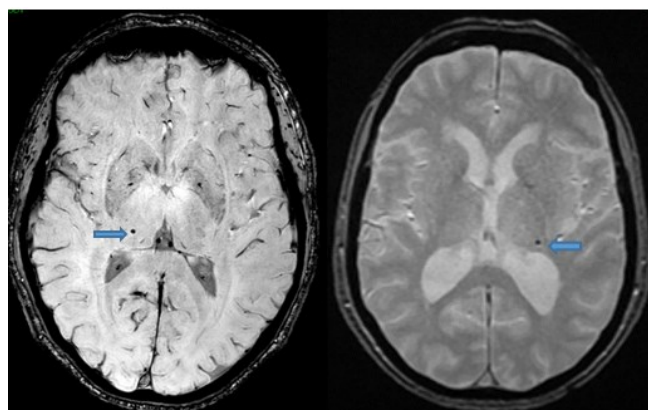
Axial (A) SWI and (B) T2* weighted MRI showing a cerebral microbleed in the basal ganglia of two participants from STRADL and LBC 1936.
